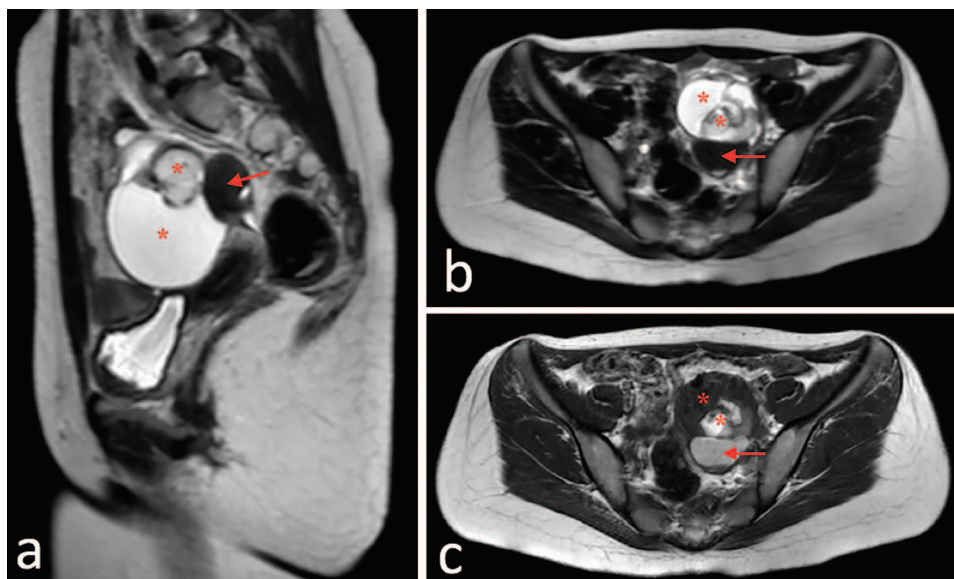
MR images of Case 2. (A) Sagittal and (B) axial T2-weighted MR images show an endometrioma (arrow) and a dermoid cyst (*) within the same ovary. Axial (C) T1-weighted MR image shows an endometrioma (arrow) and a dermoid cyst (*).
